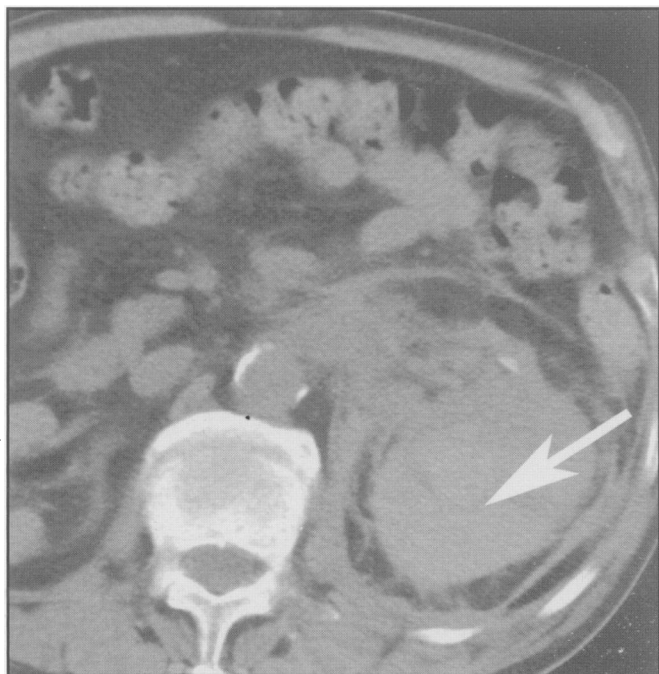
Unenhanced CT scan shows a large left perinephric hemorrhage containing a fluid-blood level (arrow).
